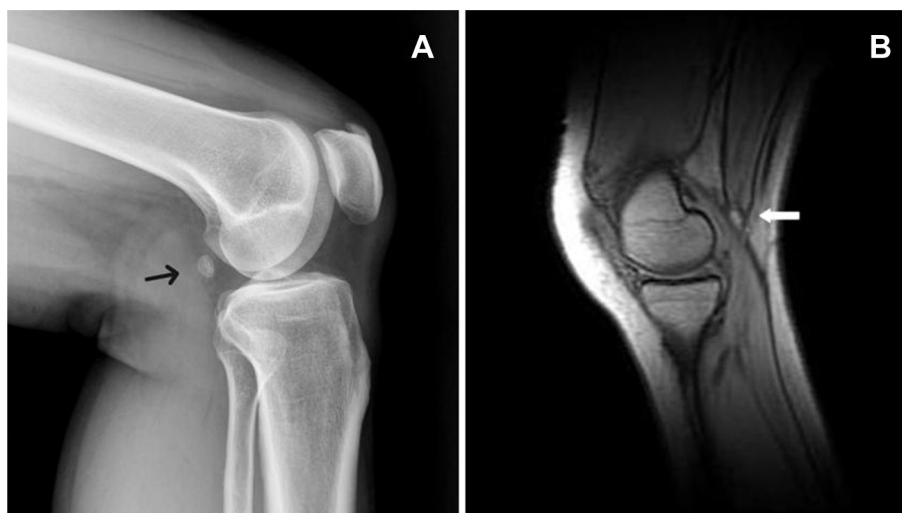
(A) X-ray of popliteal cyamella in knee OA, shown by black arrow; (B) MRI of cyamella of popliteal fossa in knee OA, shown by white arrow.
